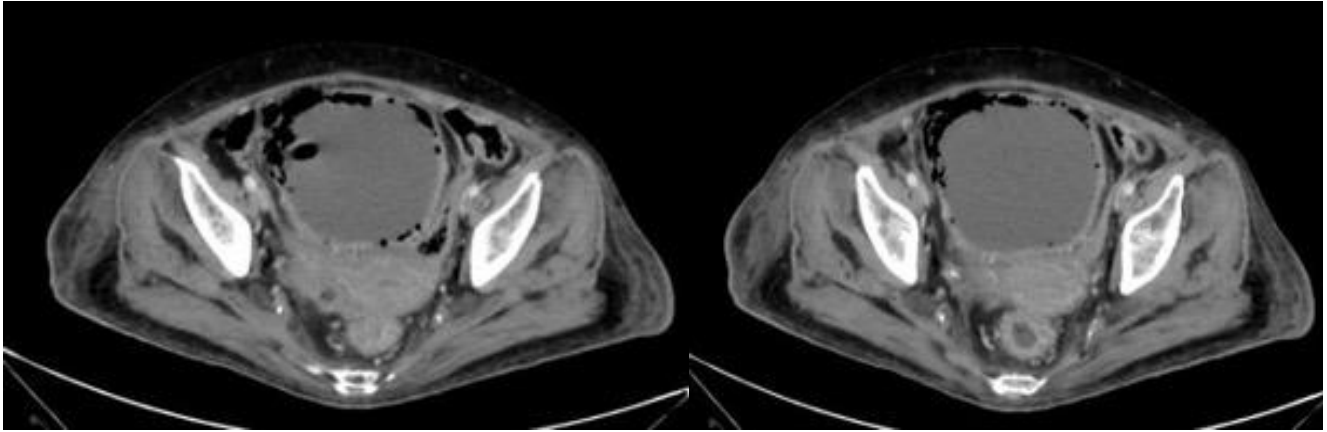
Computed tomography (axial view) also revealed multiple air foci in the bladder with thickening of the bladder.
